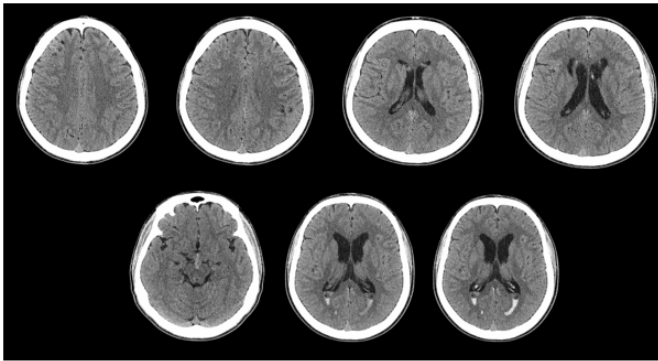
Initial brain CT (Axial slices): Petechial haemorrhagic contusions (Right frontal, left parietal, pericallosal and periventricular) with intraventricular haemorrhage.
